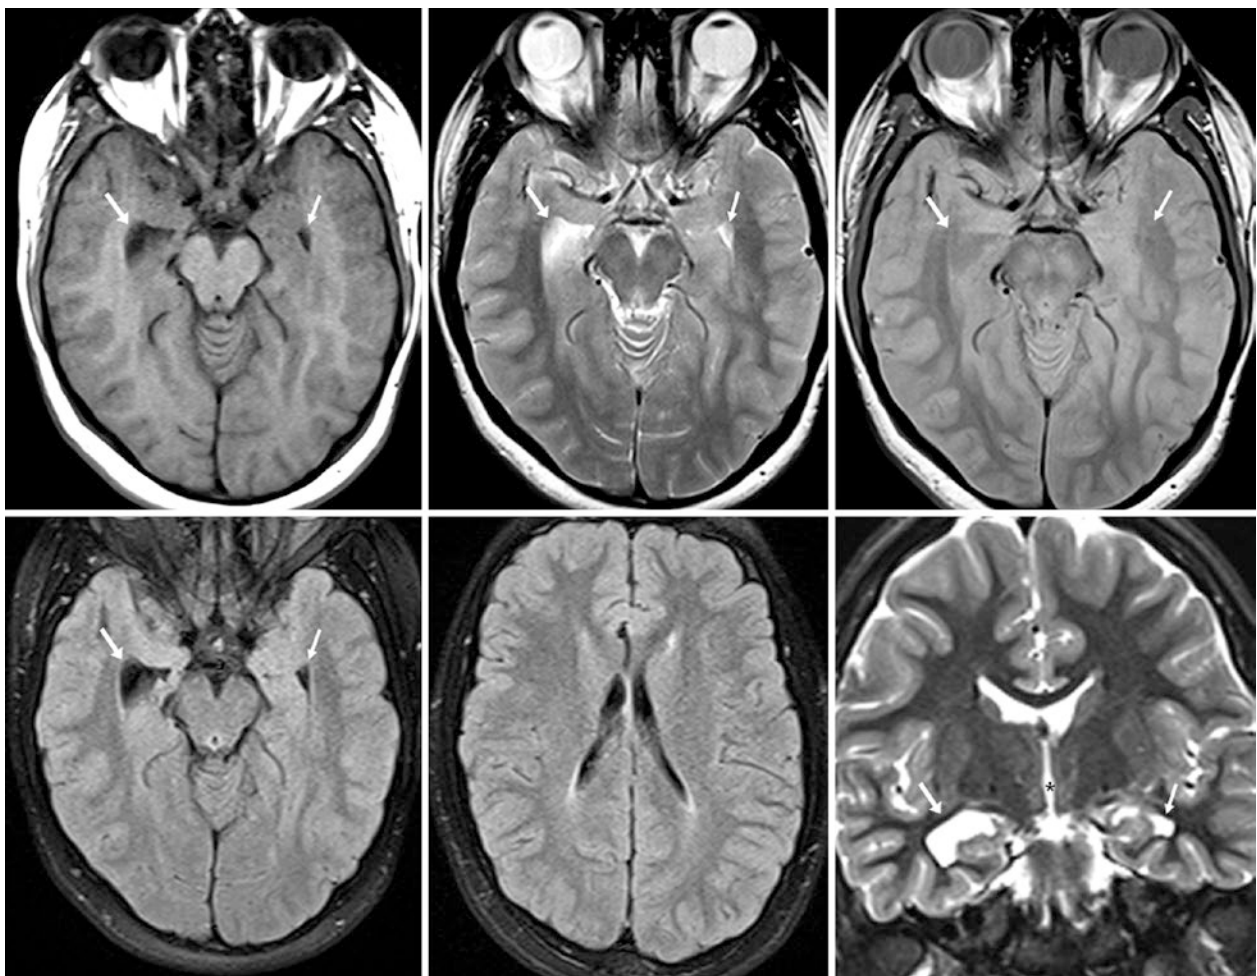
A 14 year old underwent axial T1WI (top left), T2WI (top middle), proton-density-weighted (top right), FLAIR (bottom left, and middle), and coronal T2WI (bottom right) that depicted an enlarged right temporal horn (arrows) that was focal and asymmetric. Note that
